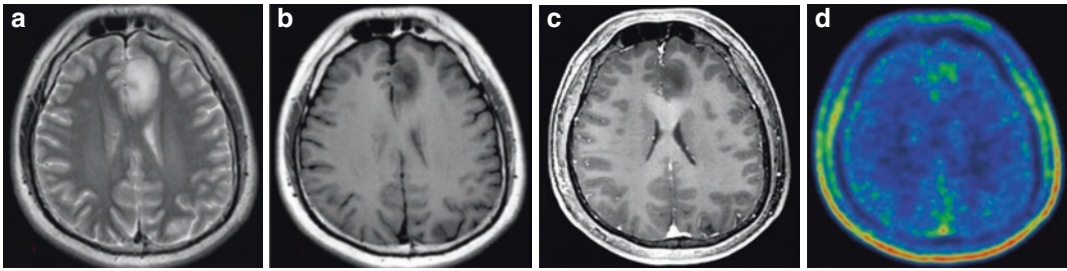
Left frontal lobe oligodendroglioma, WHO grade II. A 19-year-old male patient whose MRI shows an oval mass in the left frontal lobe. Transverse T₂WI shows heterogeneous hyperintense signals (a); transverse T₁WI
